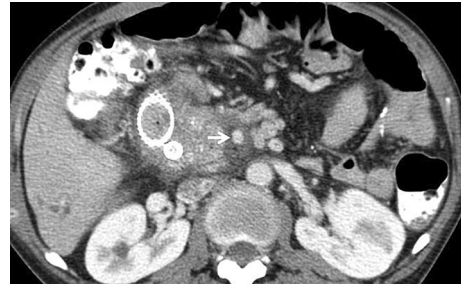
46-year-old man with history of alcohol abuse and severe chronic pancreatitis. Postsurgical CT shows the Roux-Y gastrojejunostomy and soft tissue thickening along the superior mesenteric artery (*arrow*), likely secondary to chronic fibrosis, as a feature of severe chronic pancreatitis.
